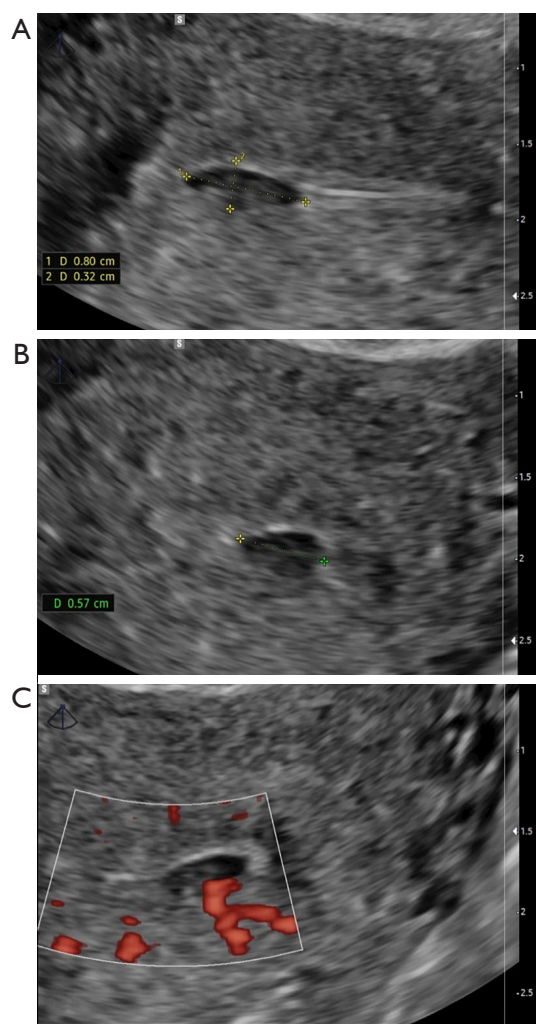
Sonographic images of UTROSCT recurrence. (A,B) Shows an hypoechoic, heterogeneous mass in the endometrium with well-defined margins; (C) shows the feeding vessel. UTROSCT, uterine tumor resembling ovarian sex-cord tumor.
